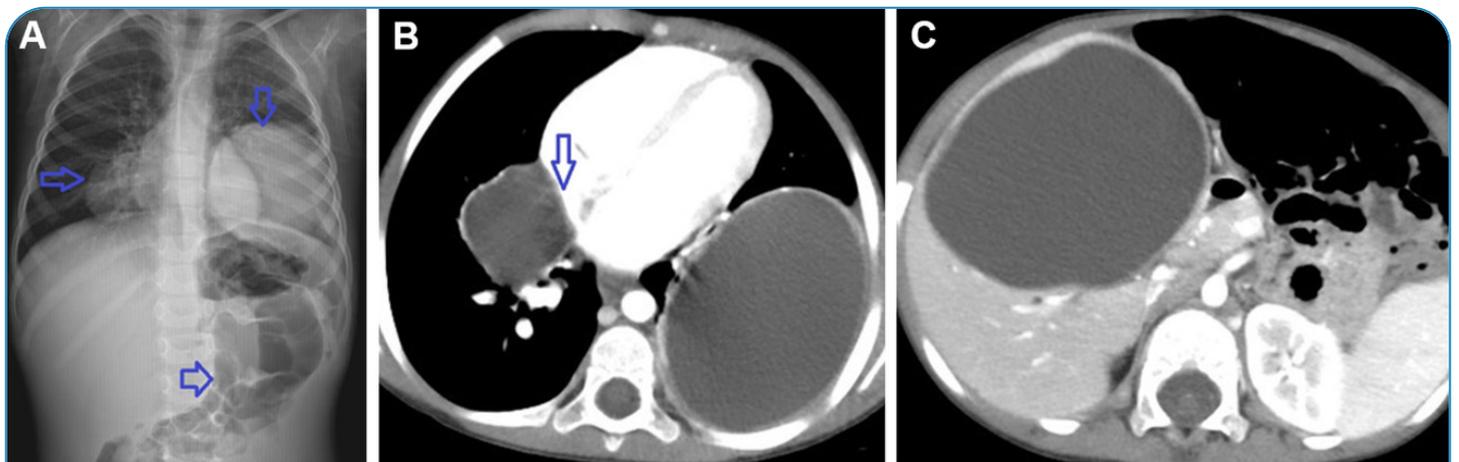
Direct radiography shows a radiopaque appearance in the right lower zone of the lung in the paracardial region and the left lower zone of the lung. The homogeneous opacity increase (arrows) pushed on the intestinal loops (A). An axial thoracic computed tomography (CT) mediastinal section shows a cyst in the right middle lobe (arrow) compressing the right atrium and a giant hydatid cyst filling the lower lobe of the left lung (B). An abdominal CT section shows a giant hydatid cyst with similar characteristics in the liver (C).
